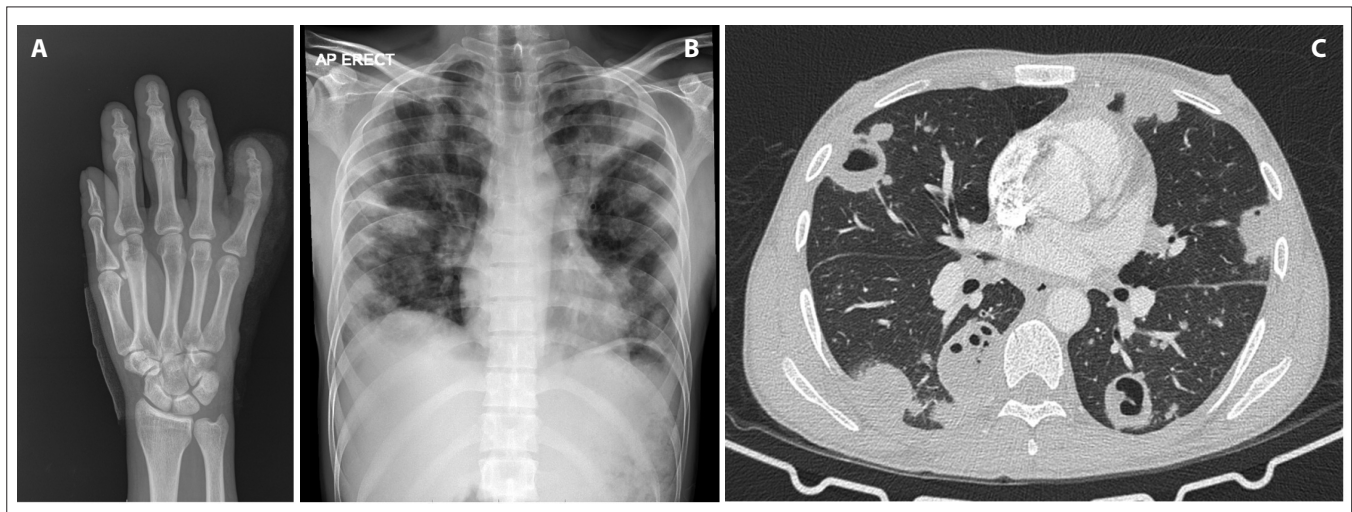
(A) Frontal radiograph of the hand demonstrating subtle irregularity of the medial cortex, periosteal reaction and soft-tissue swelling around the distal phalange of the left little finger. There is no associated joint effusion, foreign body or fracture. (B) Frontal chest radiograph showing innumerable cavitary pulmonary lesions with no zonal predilection. (C) Axial computed tomography scan of the chest in lung window confirms multiple air- and fluid-filled cavitary lesions randomly distributed within the pulmonary parenchyma.
